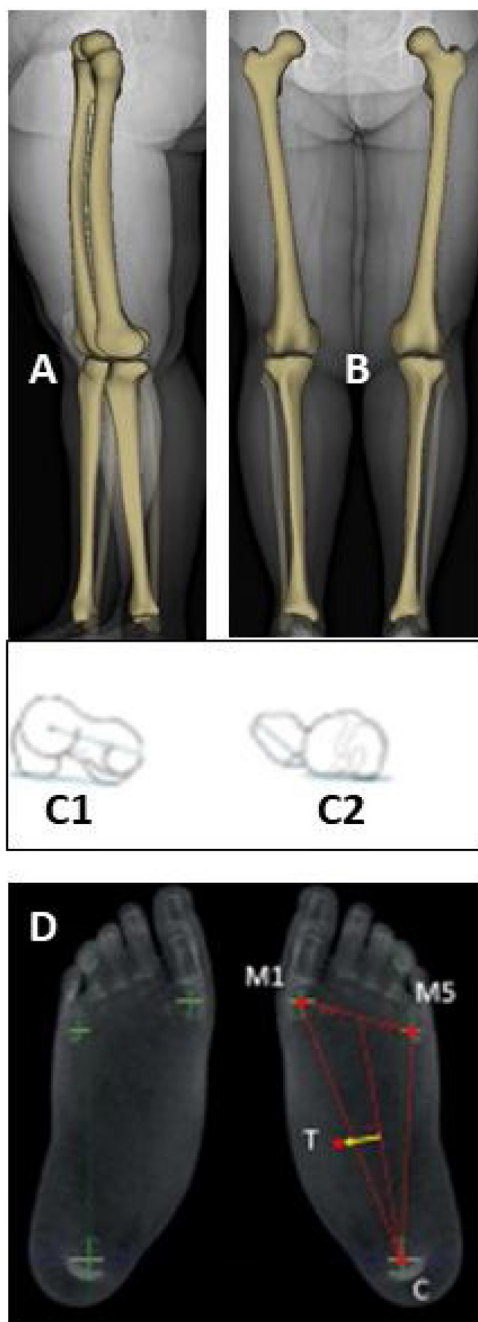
Weight-bearing lower limb imaging. Low dose biplanar radiography (A: sagittal, B: coronal) and 3D reconstruction to measure femoral (C1) and tibial (C2) torsions. Weightbearing CT to measure Foot Ankle Offset (D).
